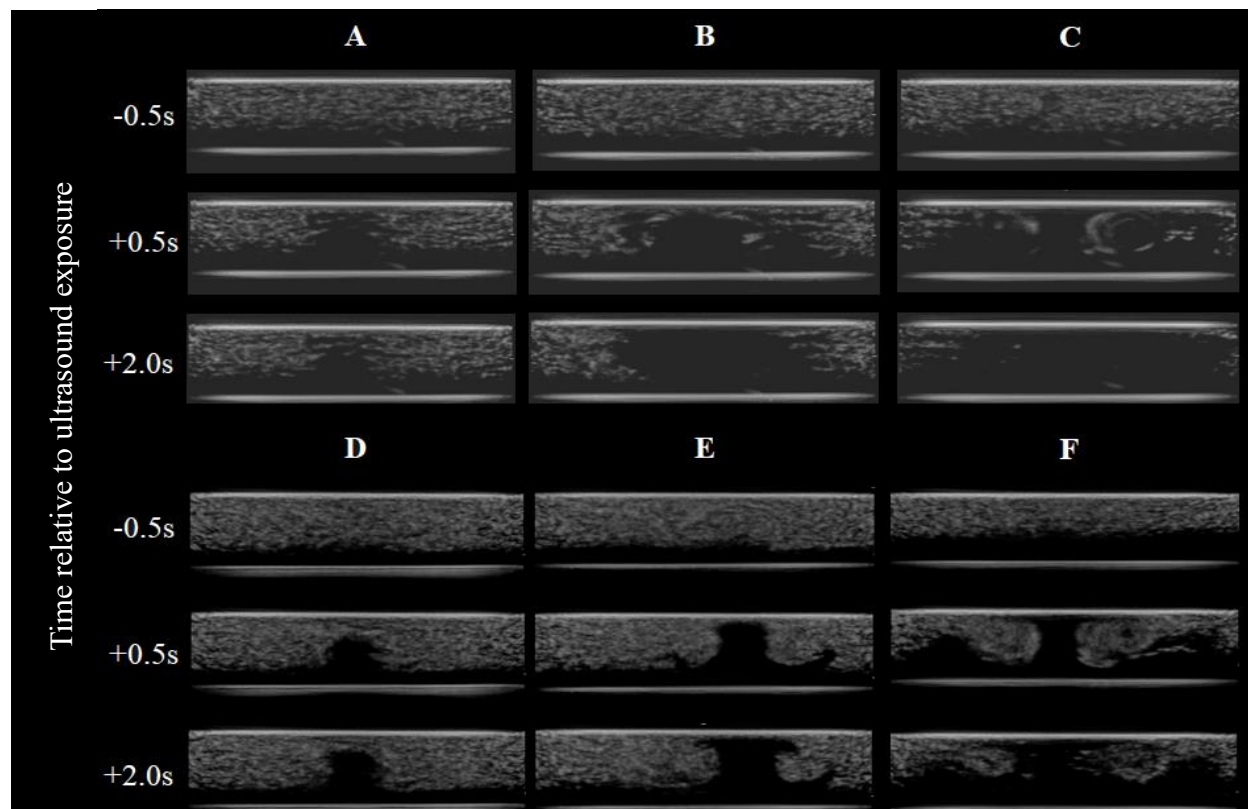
B-mode images of microbubble destruction and movement as responses to different acoustic pulses. A, B, and C are images of CLINICells filled with microbubbles at 4×10^5 MBs/ml before and after ultrasound exposure. D, E, and F are images of CLINICells filled with microbubbles at 2×10^6 MBs/ml before and after ultrasound exposure. CLINICells A and D were exposed to 200 kPa single ultrasound pulse; CLINICells B and E were exposed to 500 kPa single ultrasound pulse; CLINICell C and F were exposed to 1 MPa single ultrasound pulse. Transducer frequency (1 MHz) and pulse duration (1000 cycles) were held constant for all exposures. More microbubble destruction and acoustic streaming were observed with increased acoustic pressure.
